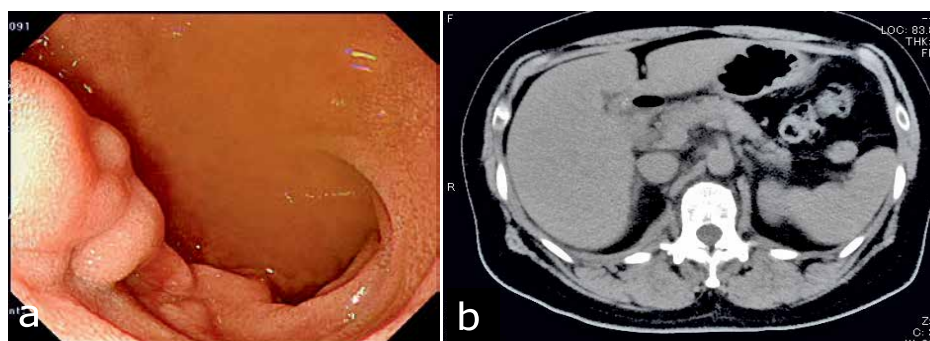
Two months later, on repeat EGD, endoscopic examination reveals that the clip has disappeared from the duodenum, and the duodenum is covered with normal mucosa surrounding the scar (a). The clip is no longer visible on abdominal CT (b).
